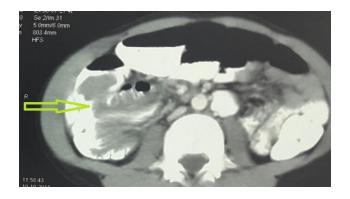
The CT scan shows; lobulated soft tissue mass (the arrow) in the transverse and descending colon (intussusceptum) in favor of intussusception.
